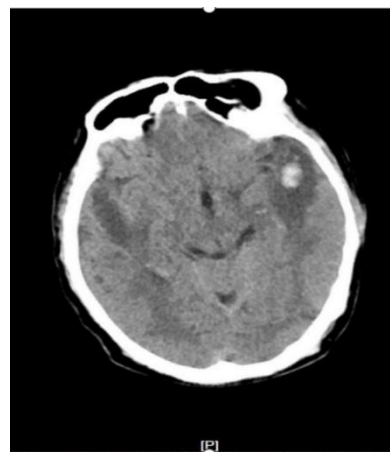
The cranial computed tomography (CT) suggests: bilateral temporal lobe hematomas with surrounding hypodense areas.
